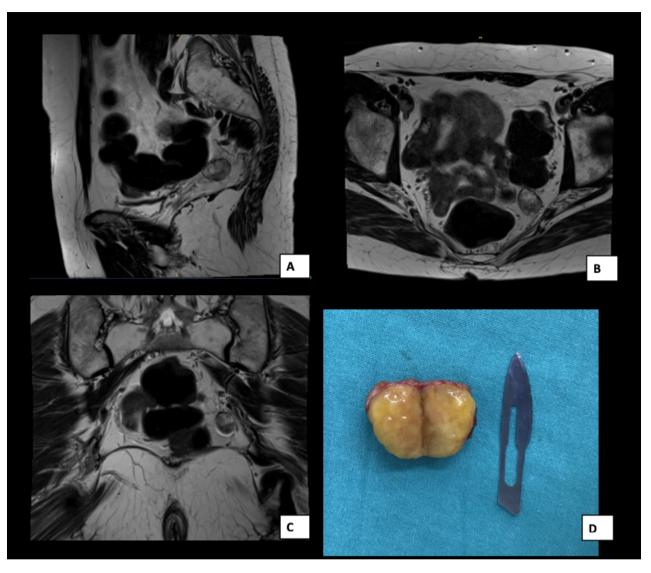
A) MRI SAGITTAL CUT OF PELVIS, HETEROGENEOUS NODULAR FORMATION AT THE RETROPERITO-NEAL LEVEL MEASURING 36 X 28 X 26 MM. B-C) AXIAL AND CORONAL CUTS. D) RESECTED TUMOR.
